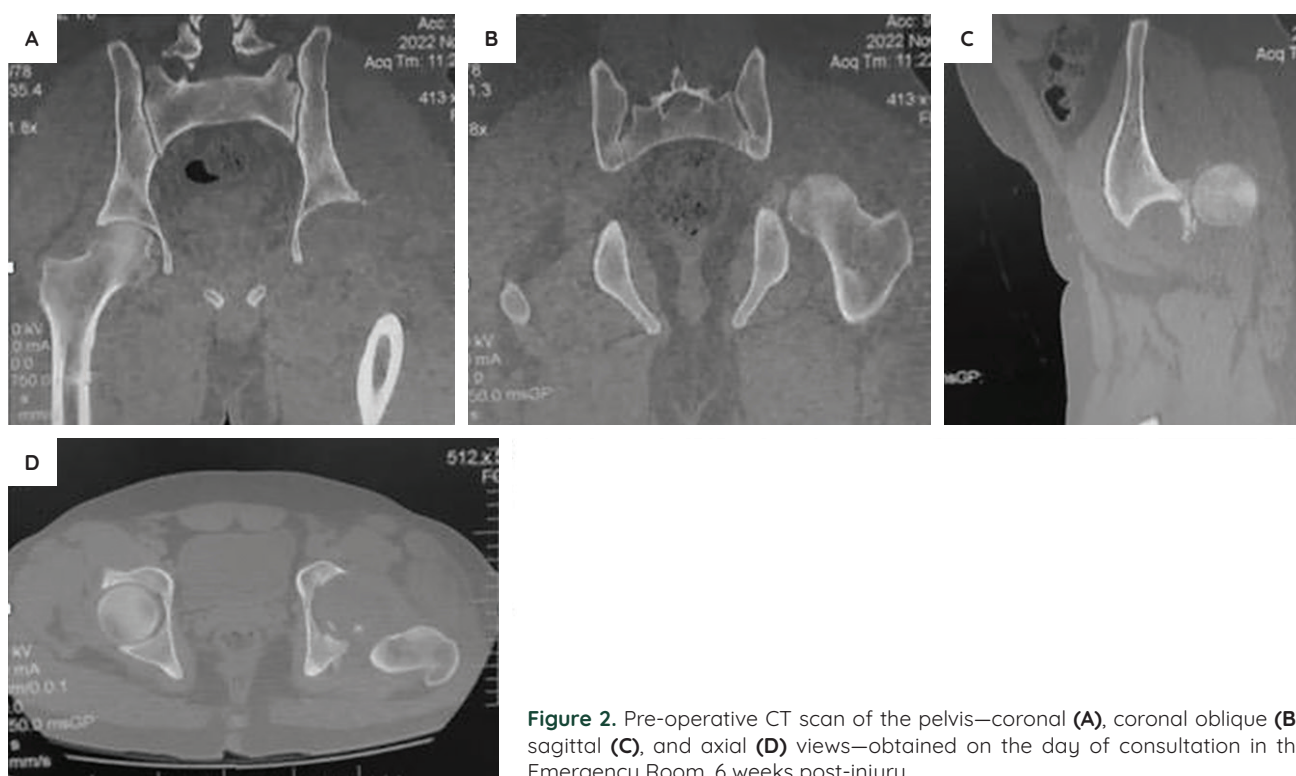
Pre-operative CT scan of the pelvis—coronal (A), coronal oblique (B), sagittal (C), and axial (D) views—obtained on the day of consultation in the Emergency Room, 6 weeks post-injury.
